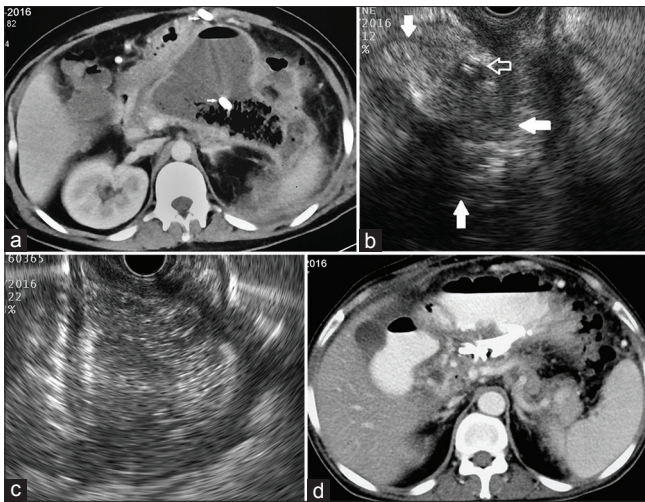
Patient with predominantly central necrosis with percutaneous catheter drainage catheter. (a) Computed tomography abdomen: Patient with percutaneous catheter drainage catheter in central necrotic collection (arrows). The collection has got walled off. (b) EUS shows a walled off necrotic collection with predominantly solid content (white filled arrows). The percutaneous catheter drainage catheter is seen inside the collection (open arrow). (c) Balloon dilatation of the transmurular tract under EUS guidance. (d) Computed tomography shows resolution of walled off pancreatic necrosis with transmurular stents *in situ*
